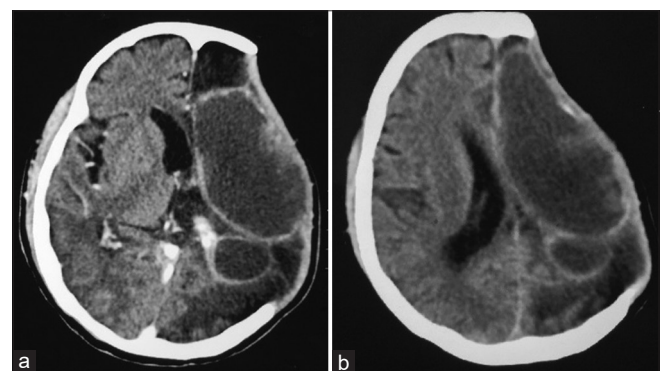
(a and b) Computed tomography brain plain showing ring-enhancing lesions in the left frontoparietal region with central hypodensity. Note the absence of any mass effect in spite of the large size of the lesion
